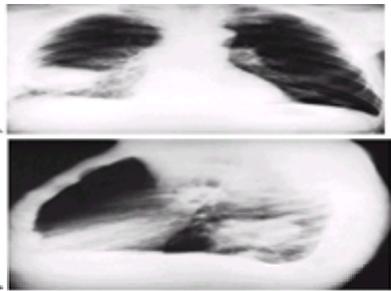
Posteroanterior (A) and lateral (B) chest roentgenograms showing a well-circumscribed homogeneous infiltrate in a patient with endogenous lipid pneumonia. (Courtesy of Dr. Robert Pugatch.)
